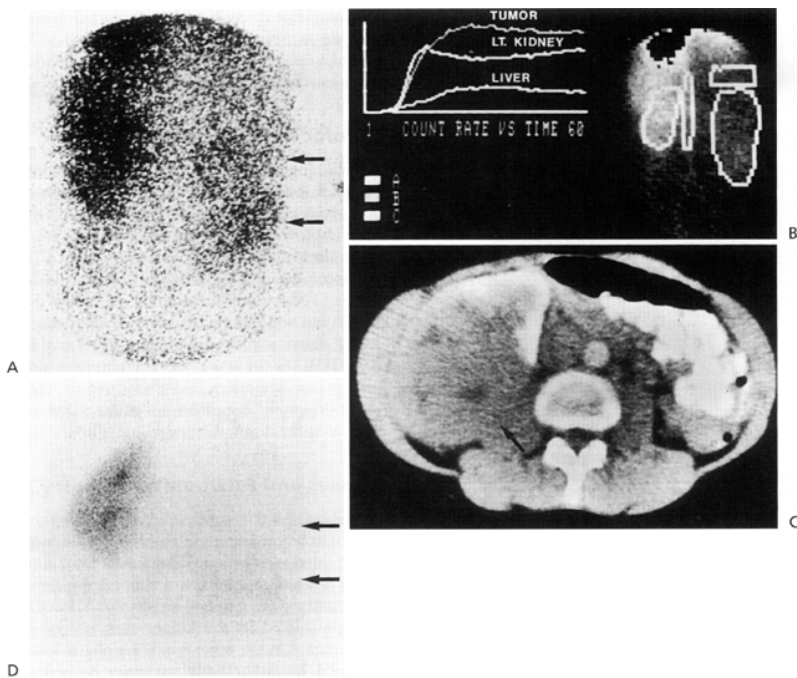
13. Woman, 38 years old, with right hypernephroma. ^{99m}Tc glucoheptonate study showed initial delay of flow to right kidney (0 to 30 seconds). A: View at 40 seconds shows definite vascularity of tumor (*arrows*). B: Histogram of blood flow to abdominal organs demonstrates initial delay in blood flow to tumor, then increased activity compared with left kidney. Normal delay in flow to liver is seen, corresponding to portal venous supply. C: Static views at 5 minutes show minimal function of right kidney, particularly in the upper pole. D: Computed tomography scan shows large right renal mass (*arrows*) with crescentic area of functioning renal tissue present along anteromedial aspect. Bowel loops in the left abdomen are opacified with oral contrast agent.
